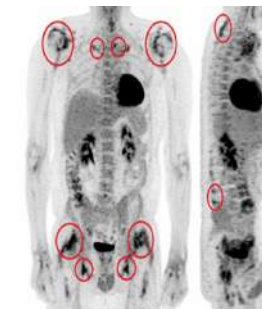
Maximum intensity projection ¹⁸F-FDG PET/CT images. SUVmax measurements were obtained in the ten regions of interest (red circles)
